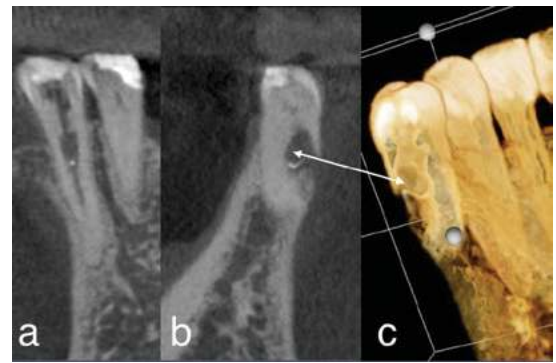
Example of the utilization of CBCT imaging in diagnosis and treatment planning of inflammatory resorptive defects. Periapical radiograph of tooth #21 (A). The patient was referred for evaluation and treatment of an internal resorptive defect. Coronal view of tooth #21 demonstrating the external/internal resorptive defect (B). 3-D reconstruction of the resorptive defect (B). Note in B and C the perforated root on the buccal aspect (white arrow) rendering tooth #21 nonrestorable. The treatment plan changed after reviewing the CBCT.
